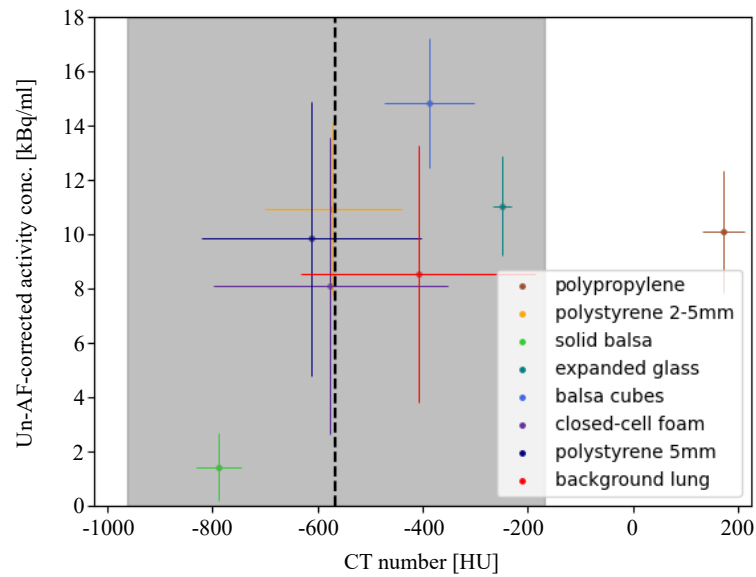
CT number versus unMF-corrected activity concentrations in unsmoothed GT for the seven features and background lung; error bars indicate one standard deviation. Black dotted line represents the mean CT number in a region of IPF in the lungs of the patient data; the shaded grey region is the range of CT numbers.
